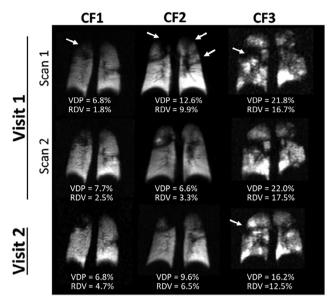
Representative single coronal Xe ventilation MRI images from Visit 1 (top two rows for Scan 1 and Scan 2) and from Visit 2 (bottom row) for three participants. VDP and RDV measurements are shown below the images. CF1 (left column) showed stable ventilation with conserved ventilation deficits appearing in the same location across all three scans, and similar VDP and RDV measurements. This stability of ventilation pattern was typical of most participants. CF2 (middle column) had large same-day ventilation changes during Visit 1, where the two scans were separated by 19 minutes; the arrows highlight ventilation deficits that were present at the first scan but not in the second scan. Notice the ventilation pattern at Visit 2 looks similar to that of Visit 1, Scan 1. For CF3 (right column), sameday ventilation in Visit 1 was consistent, but there was an improvement in ventilation at Visit 2 with a reduction in both VDP and RDV and improvement in the right-lung ventilation deficit marked by arrows. This participant had consistent 82% FEV₁ at both visits but improvement in LCI2.5 (11.573 at Visit 1, 10.542 at Visit 2).
